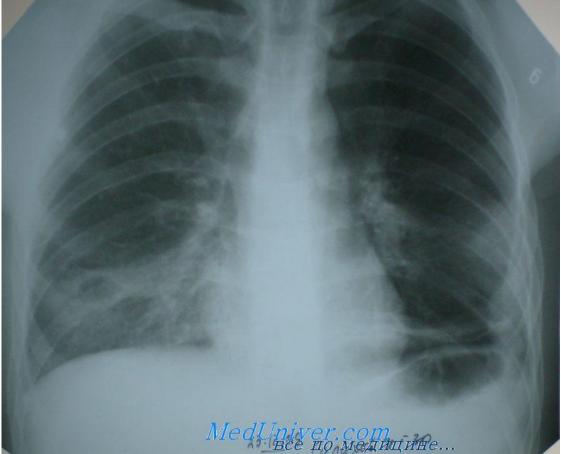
Figure to task 5. X-ray of patient S., 36 years
